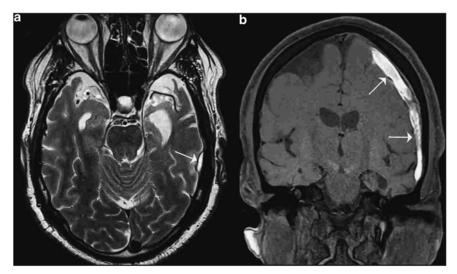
Imaging from a 59-year-old, physician with a sports-related injury (case 2). Magnetic resonance imaging showing atrophy of the frontal poles of the frontal and temporal lobes bilaterally. (a) and (b) Arrows indicate a subdural hematoma (SDH).
